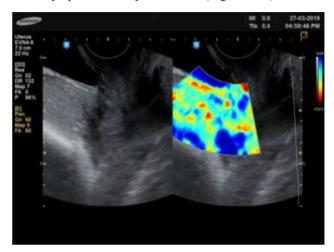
A case in which sonography and elastography showed no invasion which was confirmed intraoperatively
